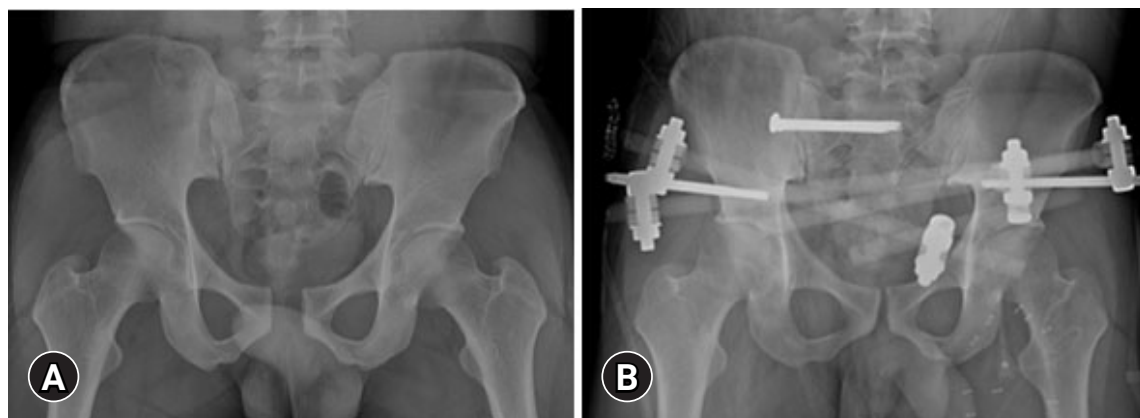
Abdominal-pelvic computed tomography (A) at the trauma bay shows an open-book type pelvic bone fracture and (B) after the operation shows the external screw fixation state.
